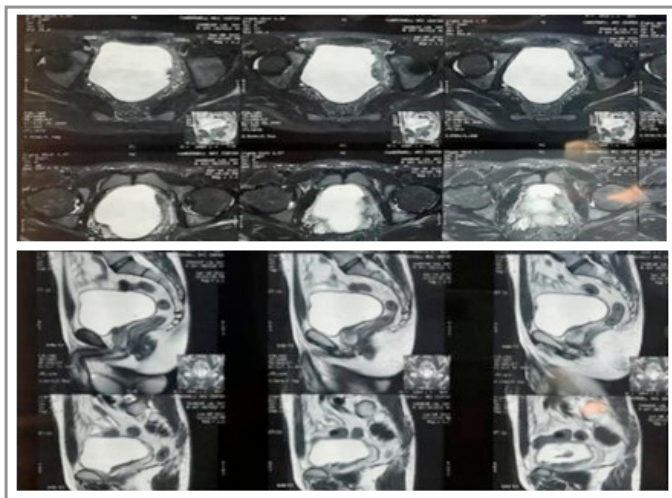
MRI images showing bladder mass on left lateral wall of UB
